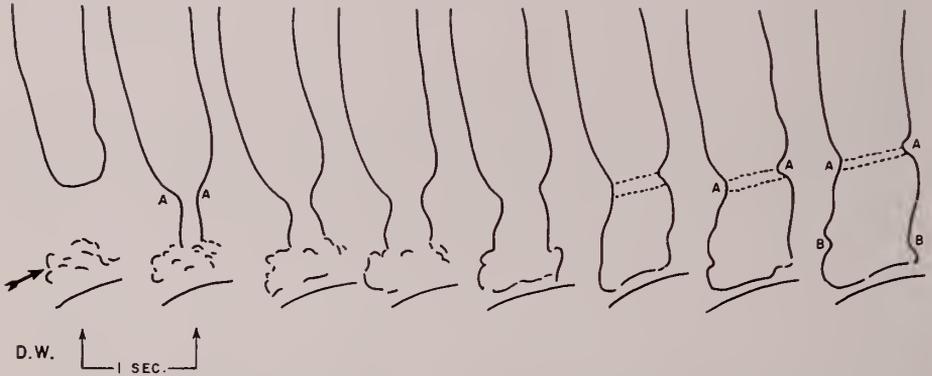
D.W. Tracings from a movie sequence. At the beginning of this sequence there was retained barium in the hernial sac, as indicated in the first frame (arrow). Barium entering the tubular esophagus was delayed for about a second at a point about 2 cm. proximal to the hernial sac. This level is indicated by the letters AA. Tracings after the first show phases of filling of the contracted segment intervening between the tubular esophagus and the hernial sac. In this patient, after filling, persistent notches and often a thin ring were seen at the AA level. Notches were also seen a short distance above the diaphragm, at the proximal margin of the hernial sac. This latter level is indicated in the last frame by the letters BB. A photograph of the last frame is shown in Fig. 3A. A spot radiograph of this same patient in a similar phase is shown in Fig. 7A.
